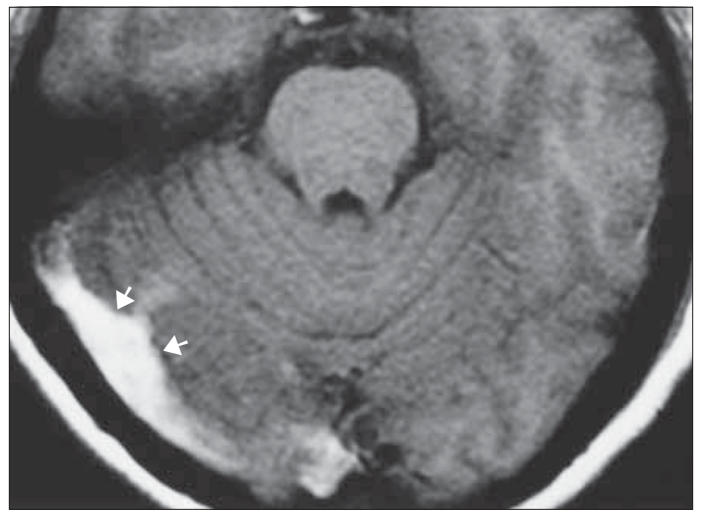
Axial T1-weighted MR image demonstrates a high-signal-intensity mass (arrows) in the right transverse sinus.
